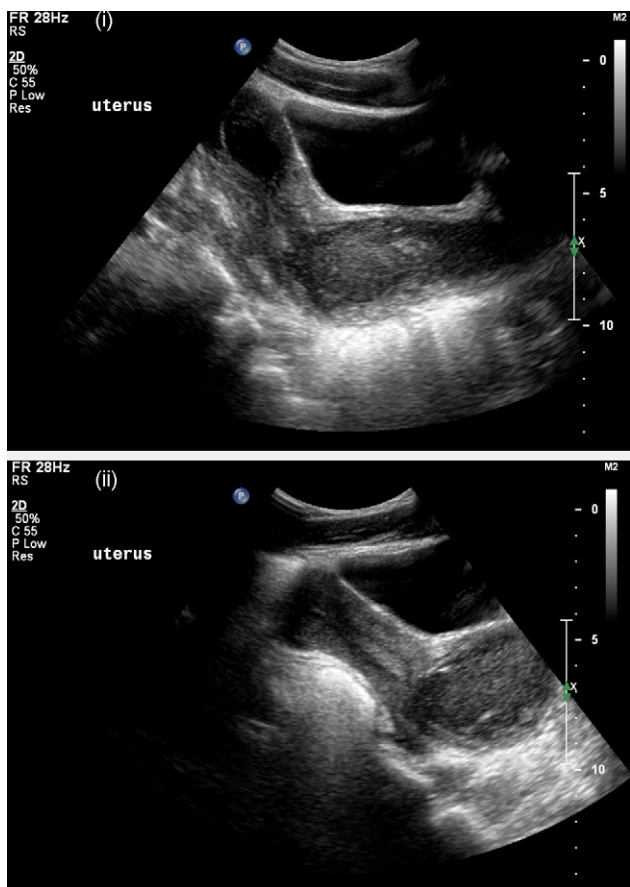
Sagittal section ultrasound image demonstrates (i) distended, fluid filled right uterine horn and haematocolpos (ii) left uterine horn and haematocolpos. Key: A – right endometrioma; B – haematometracolpos complex.
